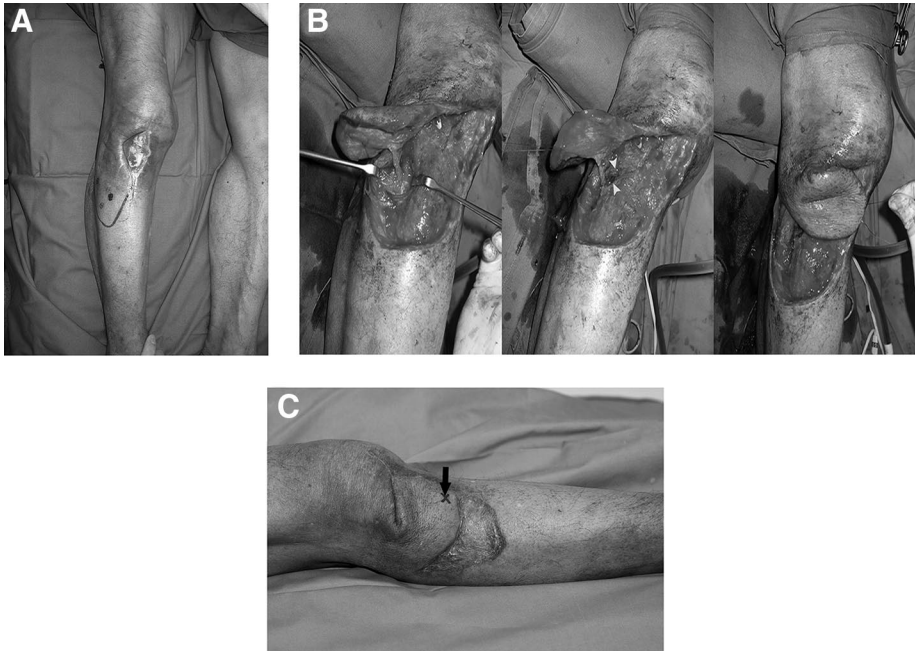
Patient of Case 2. A, Right knee wound. Preoperative markings of a perforator-sparing transposition flap. B, Left, Intraoperatively the selected perforator was a septocutaneous perforator, and this was mobilized to its origin at the anterior tibial artery. An unfavorable configuration with the perforator running away from the center of transposition was noted. Middle, To facilitate transposition without tension of the perforator, approximately 40% of the tibialis anterior muscle (arrowheads) was cut to create a more direct path from the origin of the perforator to the flap. Right, Wound closed with the perforator-sparing transposition flap. C, Patient at 6-month follow-up. Doppler assessment confirmed the patency of the preserved perforator (arrow).
